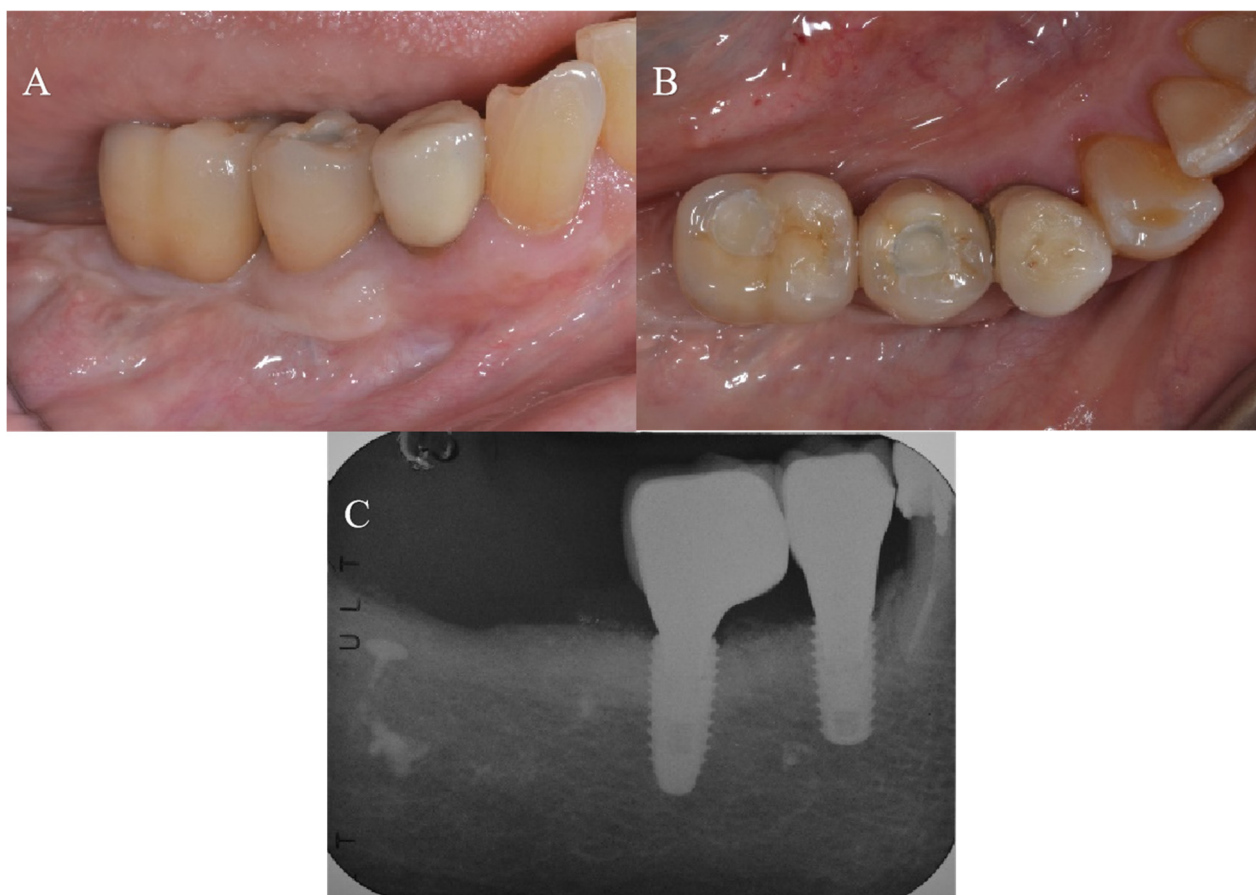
The 1 year clinical (A, B) and radiographic (C) follow-up after prosthetic loading showed excellent hard and soft tissues maintenance of the screw-retained porcelain-fused-to-metal crowns.
